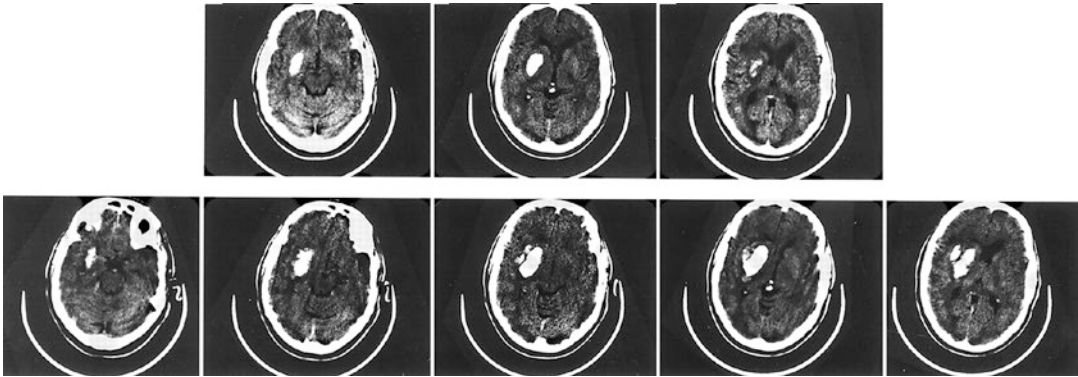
Axial CT brain demonstrating right putaminal hemorrhage (From Brott et al. [1]. Reprinted with permission from Wolters Kluwer Health, Inc.)
